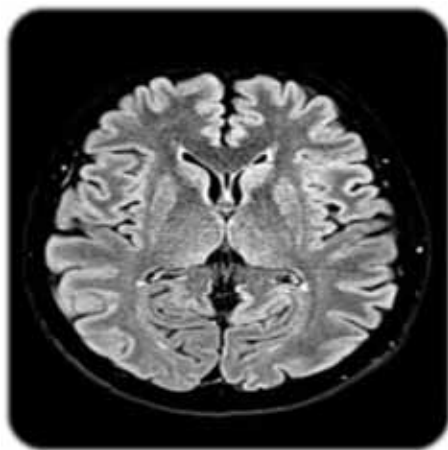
FLAIR increase of signal of the head of left N. Caudatus
